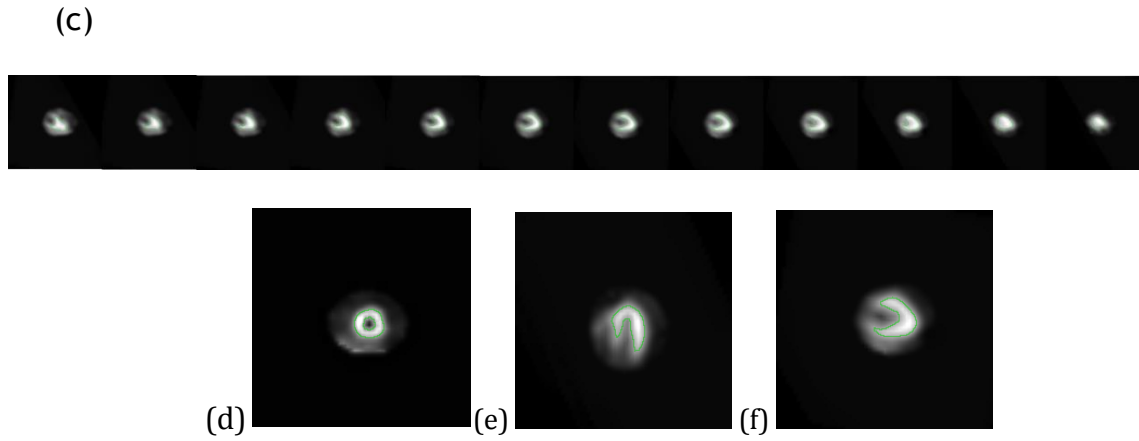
Segmented template stress SPECT image obtained using computer image registration techniques: (a) SA ; (b) HLA ; (c) VLA; (d) Zoomed SA example slice; (e) Zoomed HLA example slice; (f) Zoomed VLA example slice.
